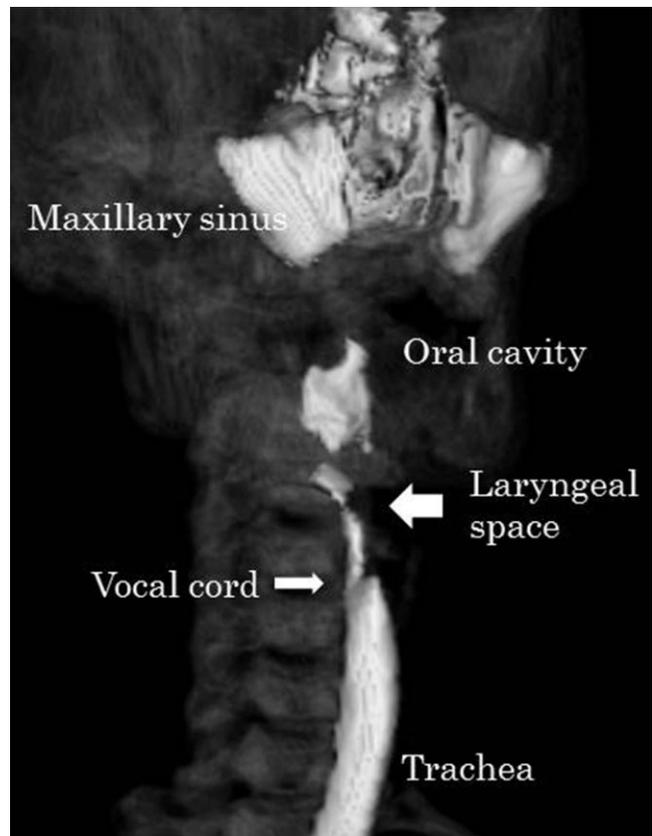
The reconstructed image of post-mortem computed tomography for the airway of the patient. The airway above the vocal cord was completely obstructed. The base of tongue is also occupied by soft tissues.
